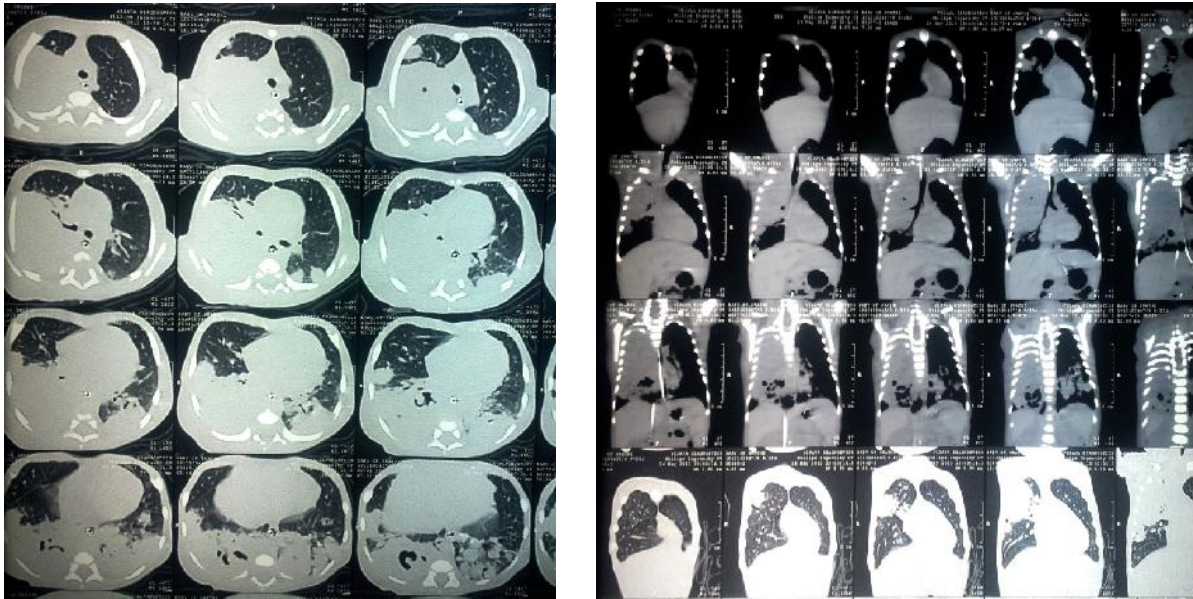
Multiple confluencing nodular lesions with curvilinear air lucencies in Chest CT scan
